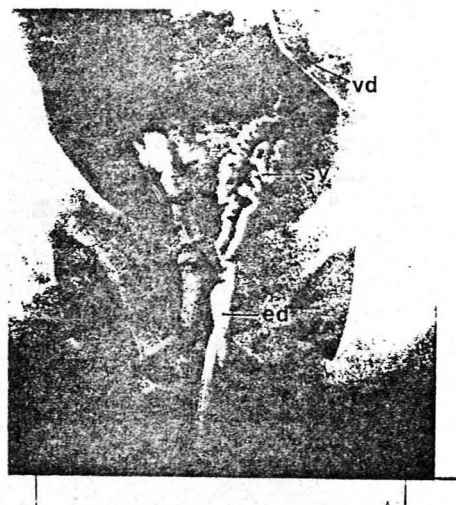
X-Ray film of the abdomen of Case 1 after injection of contrast dye into the vas deferens at the time of abdominal exploration.
